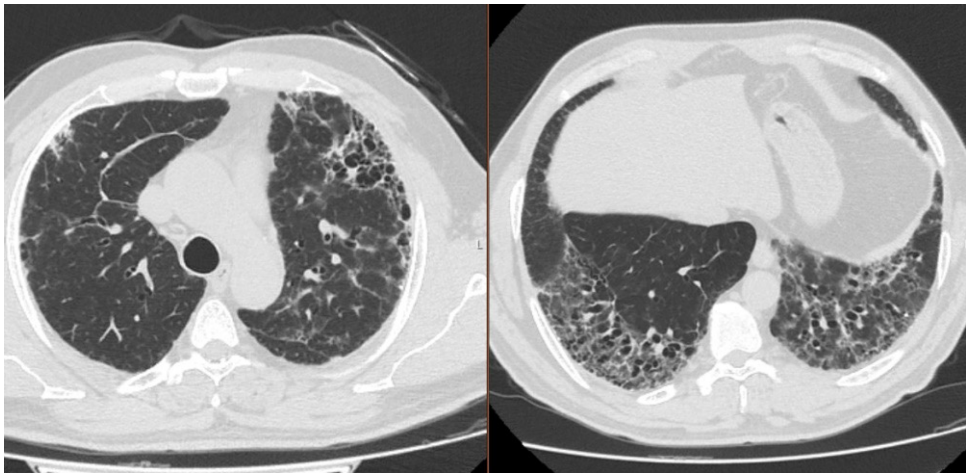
Patient’s Chest CT at the time of diagnosis.
